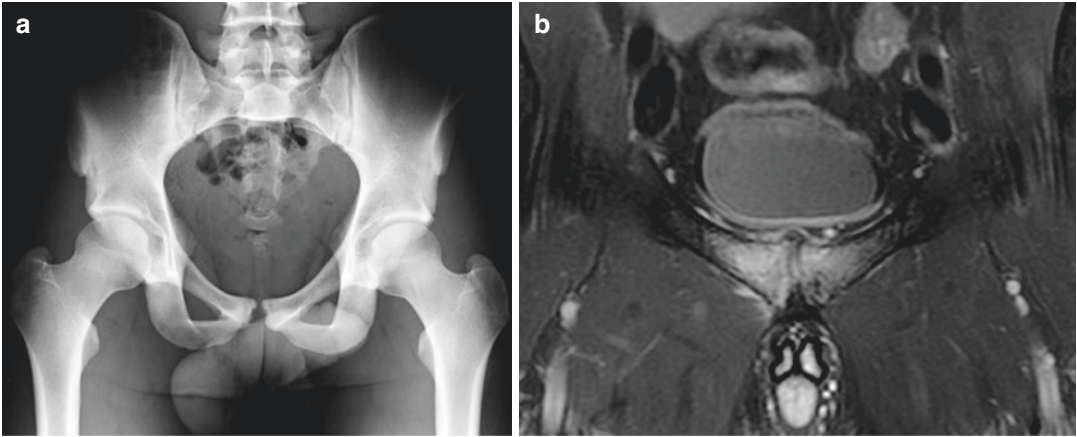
(a) RX AP pelvis and (b) MRI coronal STIR. Signs of arthrosis are visible in this RX study, associated with bilateral BME on MRI imaging
